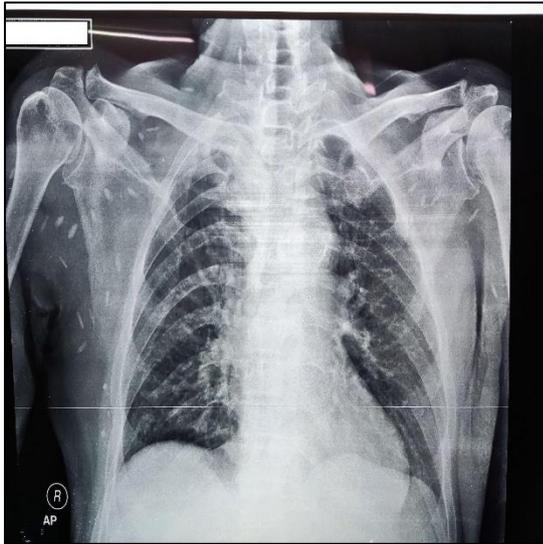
Anteroposterior (AP) chest X-ray with rice grain calcification appearance.
